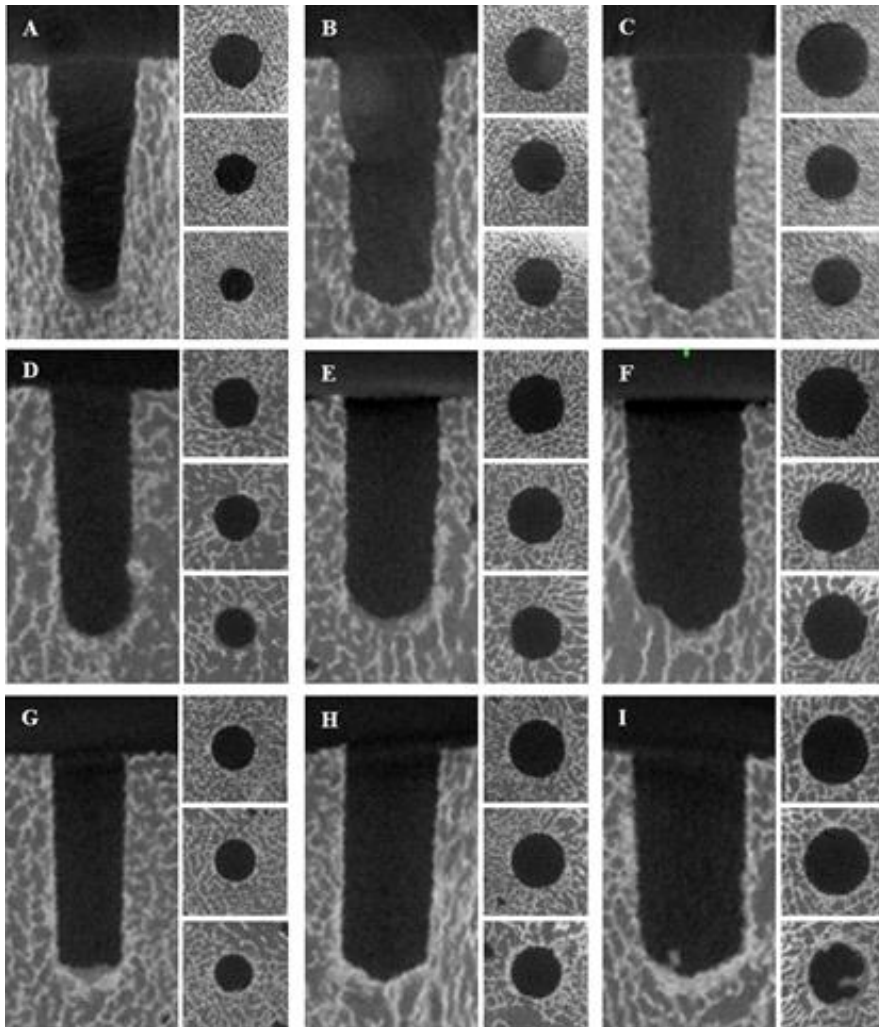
Comparison of bone density around the drilling holes on micro-positron emission tomography/computed tomography images according to diameters and techniques. A: conventional technique (CD) with 3.8 mm drilling, B: CD with 4.8 mm drilling, C: CD with 5.8 mm drilling, D: osseodensification technique in the clockwise direction (OD-C) with 3.5 mm drilling, E: OD-C with 4.5 mm drilling, F: OD-C with 5.5 mm drilling, G: osseodensification technique in the counter-clockwise direction (OD-CC) with 3.5 mm drilling, H: OD-CC with 4.5 mm drilling, I: OD-CC with 5.5 mm drilling.
